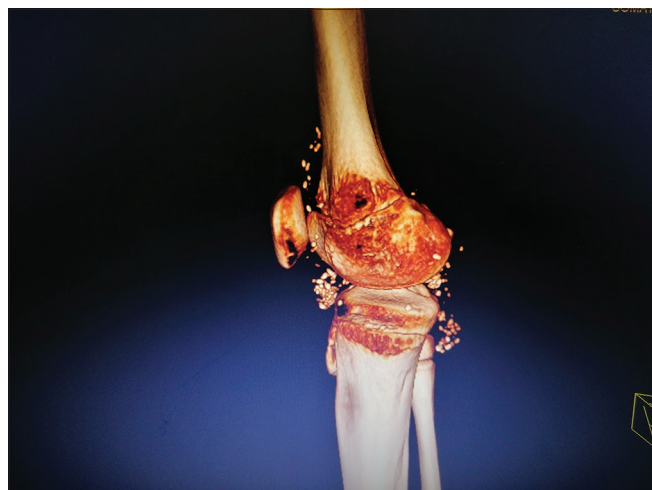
CT with 3D reconstruction shows disseminated knee nodules. The gold standard for diagnosis of synovial osteochondromatosis. CT: Computed tomography.
